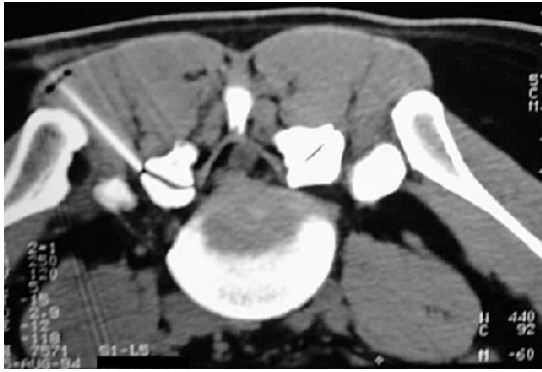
CT control of local anesthesia
